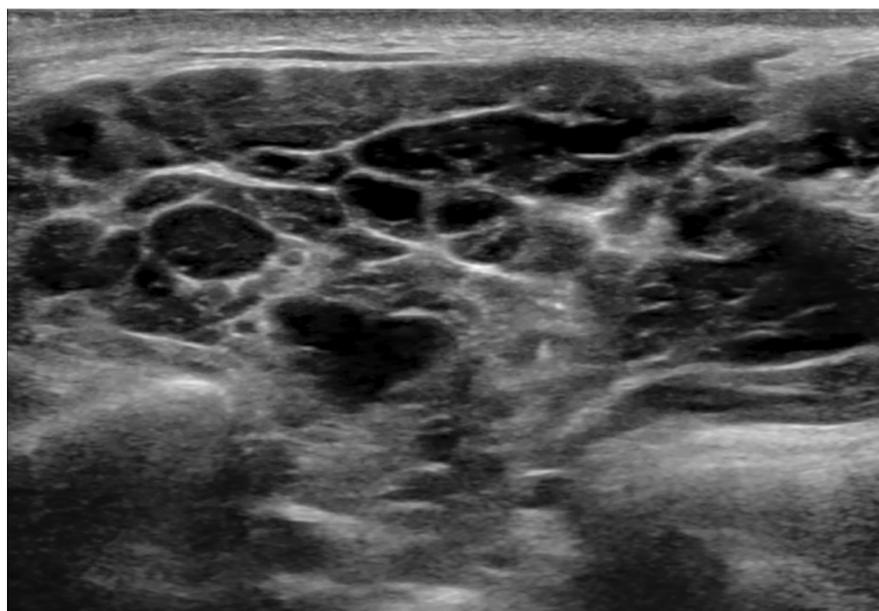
Ultrasonographic image of a parotid gland of a patient diagnosed with lymphoma.
